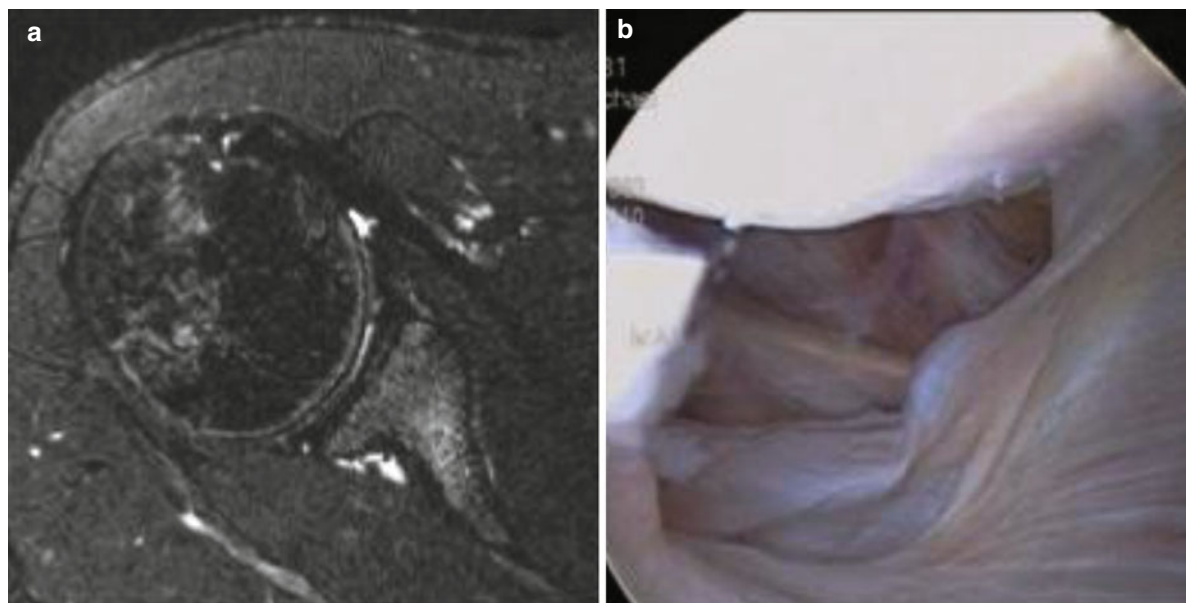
HAGL-lesion. (a) Axial sequence of MRI. (b) Intraoperative picture
